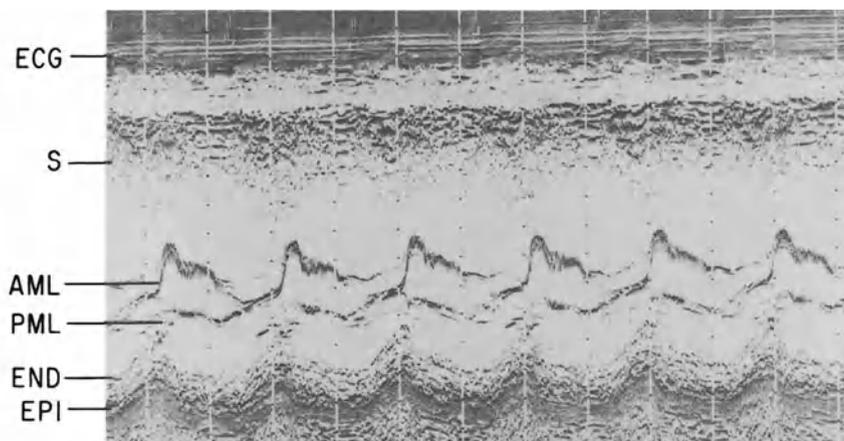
Flutter of the anterior mitral leaflet (AML) in a 60-year-old patient with significant aortic insufficiency and secondary diastolic rumble at the apex. Echocardiogram shows a normal posterior mitral leaflet (PML) and no evidence of mitral stenosis. S = septum, END = endocardium, EPI = epicardium.
